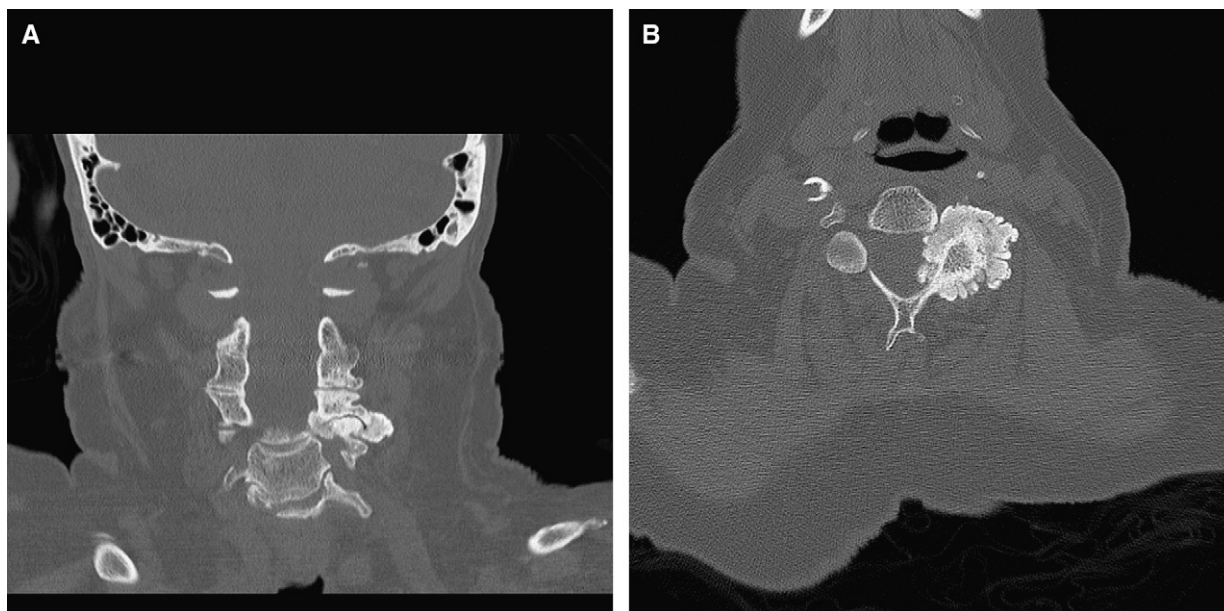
Anteroposterior (A) and lateral (B) computed tomography images of this cervical spine show unusually prolific hypertrophic arthrosis of the facet joint producing severe narrowing of the left C4-5 foramina consistent with a C5 radiculopathy.
